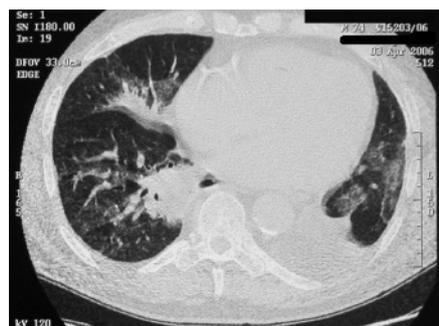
CT scan of the thorax showing left lower lobe collapse with dense consolidation in the posterior aspect of the right middle and lower lobes.
